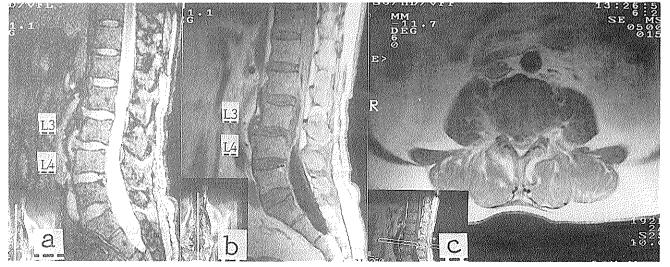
MRI of L-S spine at admission. (a): sagittal T2*WI showing decreased in height of L3-L4 IVD with peripheral extention of the disc material. (b): epidural lesion from L2 to L4 on Gd-T1WI. (c): axial Gd-T1WI showing poorly-defined enhanced shadows over bilateral psoas muscles.
